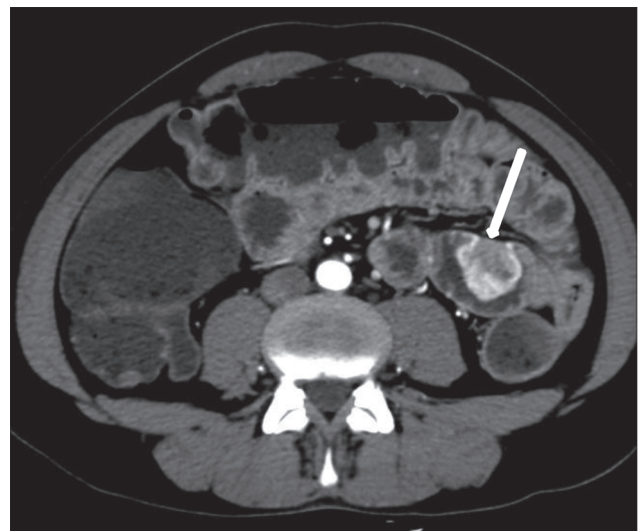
Axial contrast-enhanced CT image showing intensely enhancing completely endophytic jejunal gastrointestinal stromal tumor (GIST). Low risk. Mitotic index (MI) < 5/50 HPF. Size: 3 cm.
